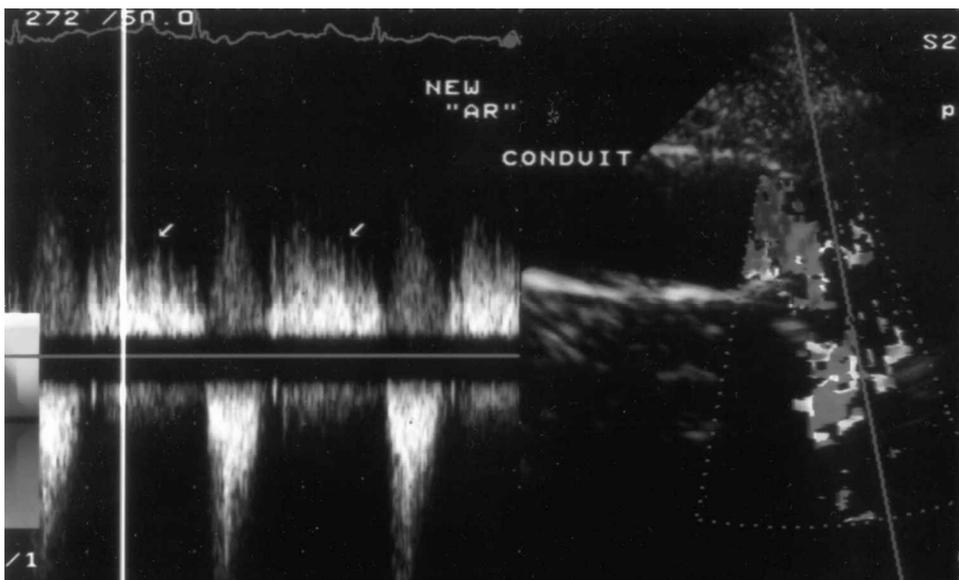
TTE with pulsed-wave Doppler at the apex demonstrates conduit prosthetic valve regurgitation (arrows).
